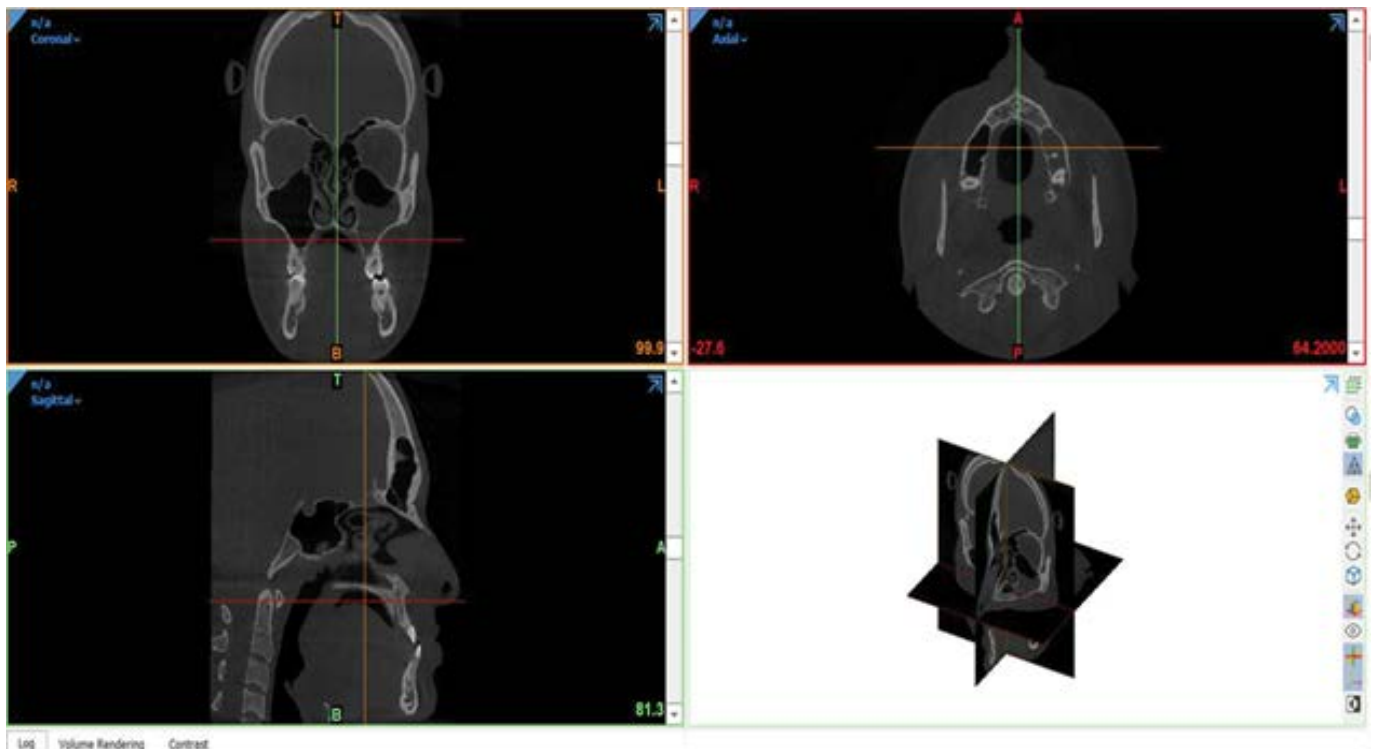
CT scan images.
